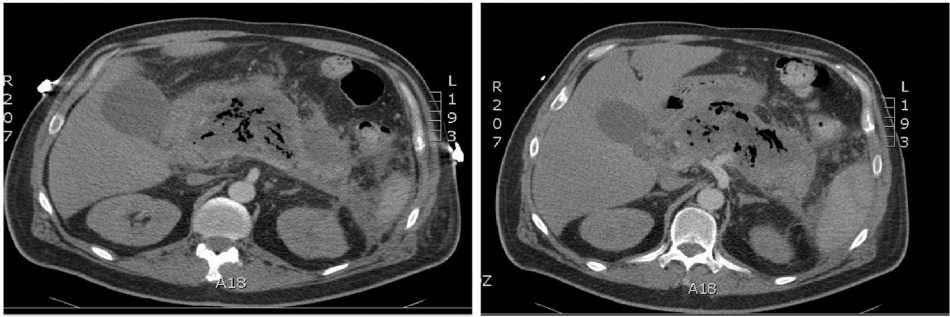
Enhanced CT scan of infected pancreatic necrosis shows extraluminal gas within pancreatic collection.
